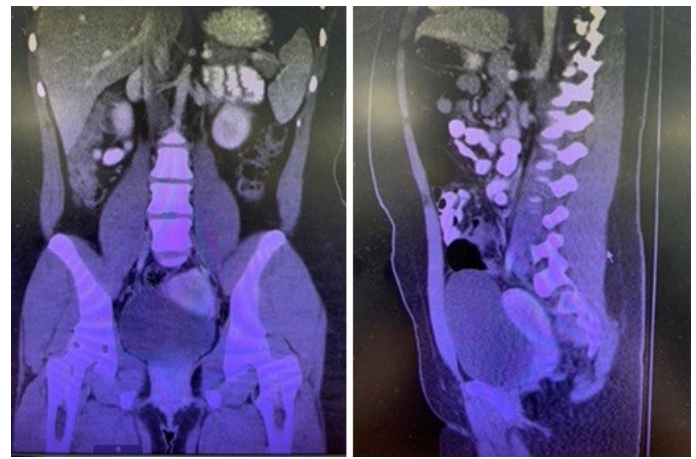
Computed Tomography (CT) of the abdomen detected right lower quadrant/pelvic homogeneous solid mass, suspected for right ovarian origin. Mass measures approximately 8.5 x 6.1 x 7.4 cm.
